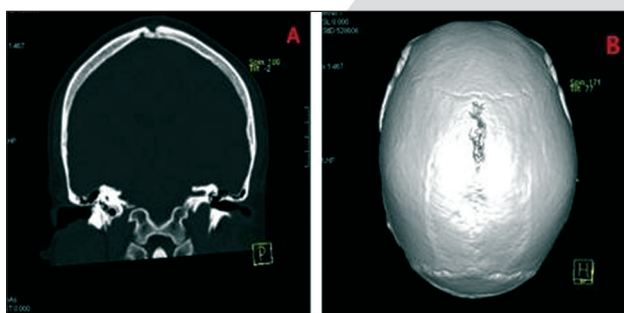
There was an obvious bone destruction in CT and 3D-CT reconstruction
